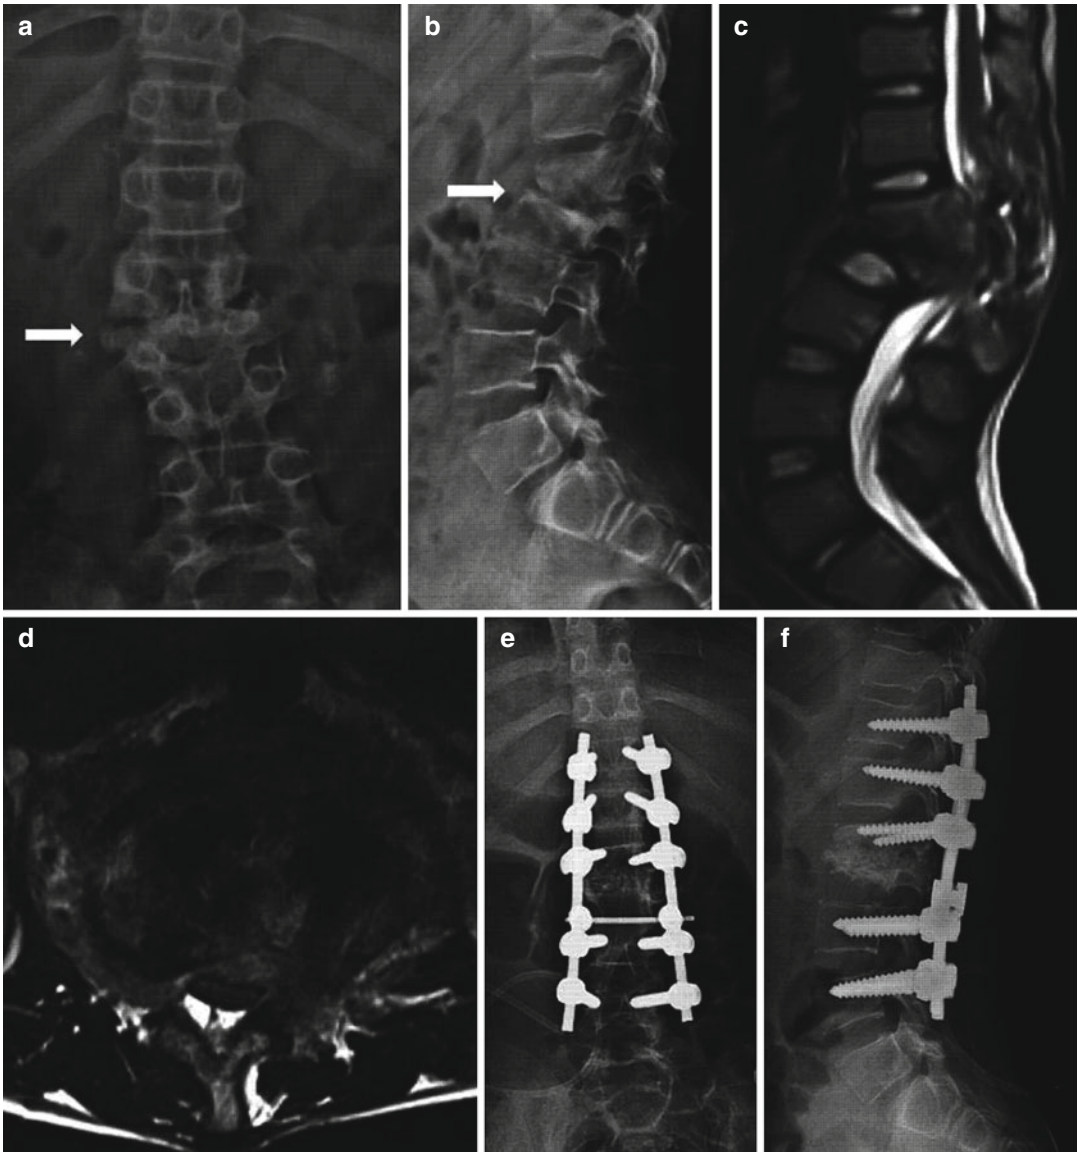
This 13 year old boy had developed L1-2 tuberculosis and kyphosis with conus medullaris syndrome. (a, b) The anteroposterior and lateral radiographs show the vertebral damage and local kyphosis (white arrows). Sagittal and axial MR images show abscess
